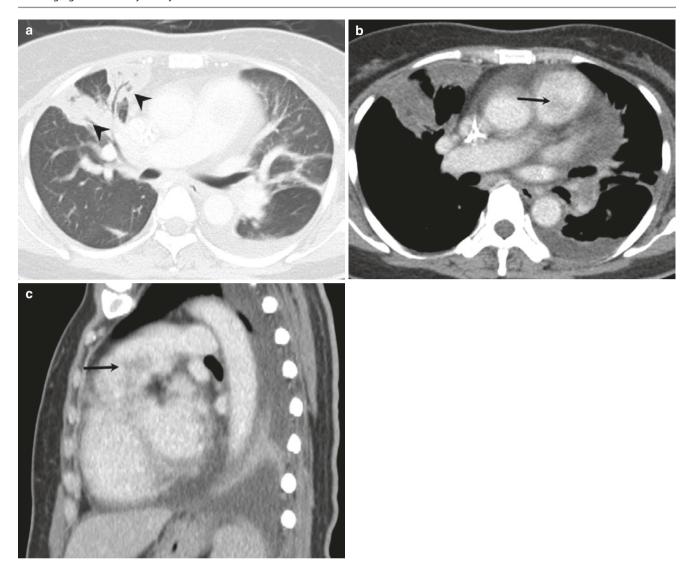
Pulmonary valve infective endocarditis with septic pulmonary emboli. (a) Axial CT image shows peripheral peribronchial consolidations (arrowheads) in the anterior right upper lobe. (b, c) Axial
